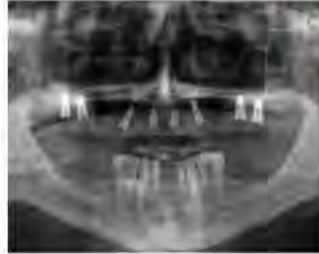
Radiograph after healing completed following bilateral sinus augmentation placement of implants to support a full arch hybrid prosthesis.
